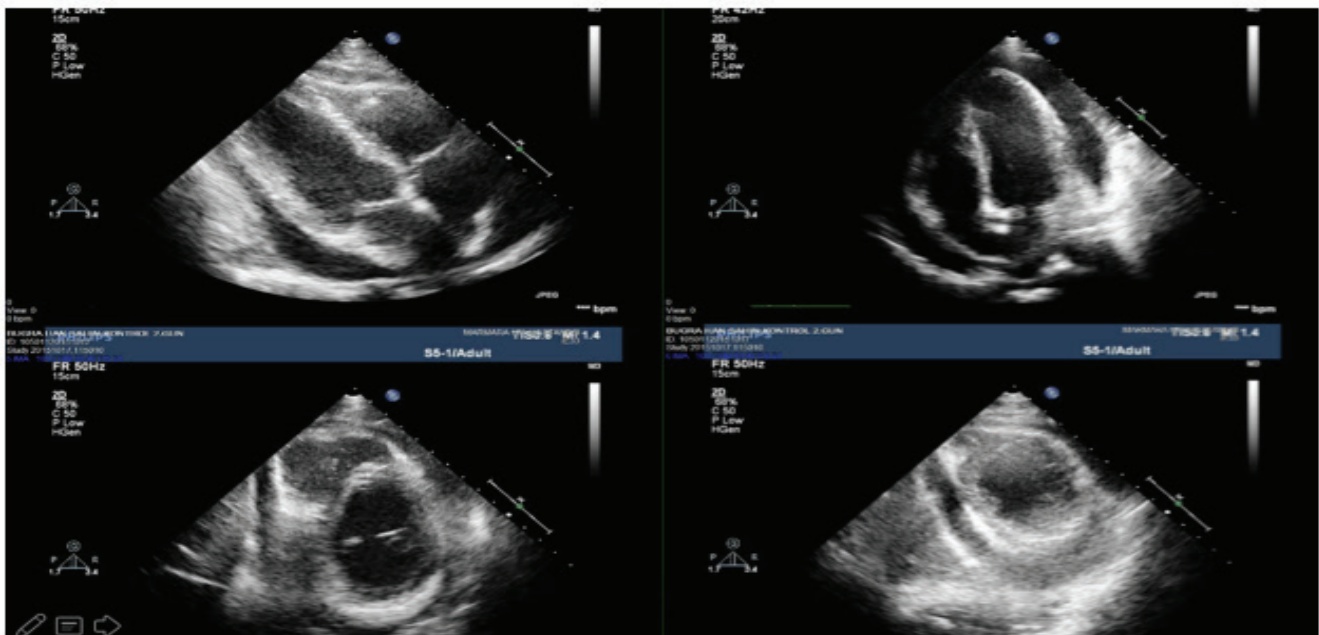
Decreasing amount of effusion and absence of right ventricular diastolic collapse were seen in echocardiographic images after PC
